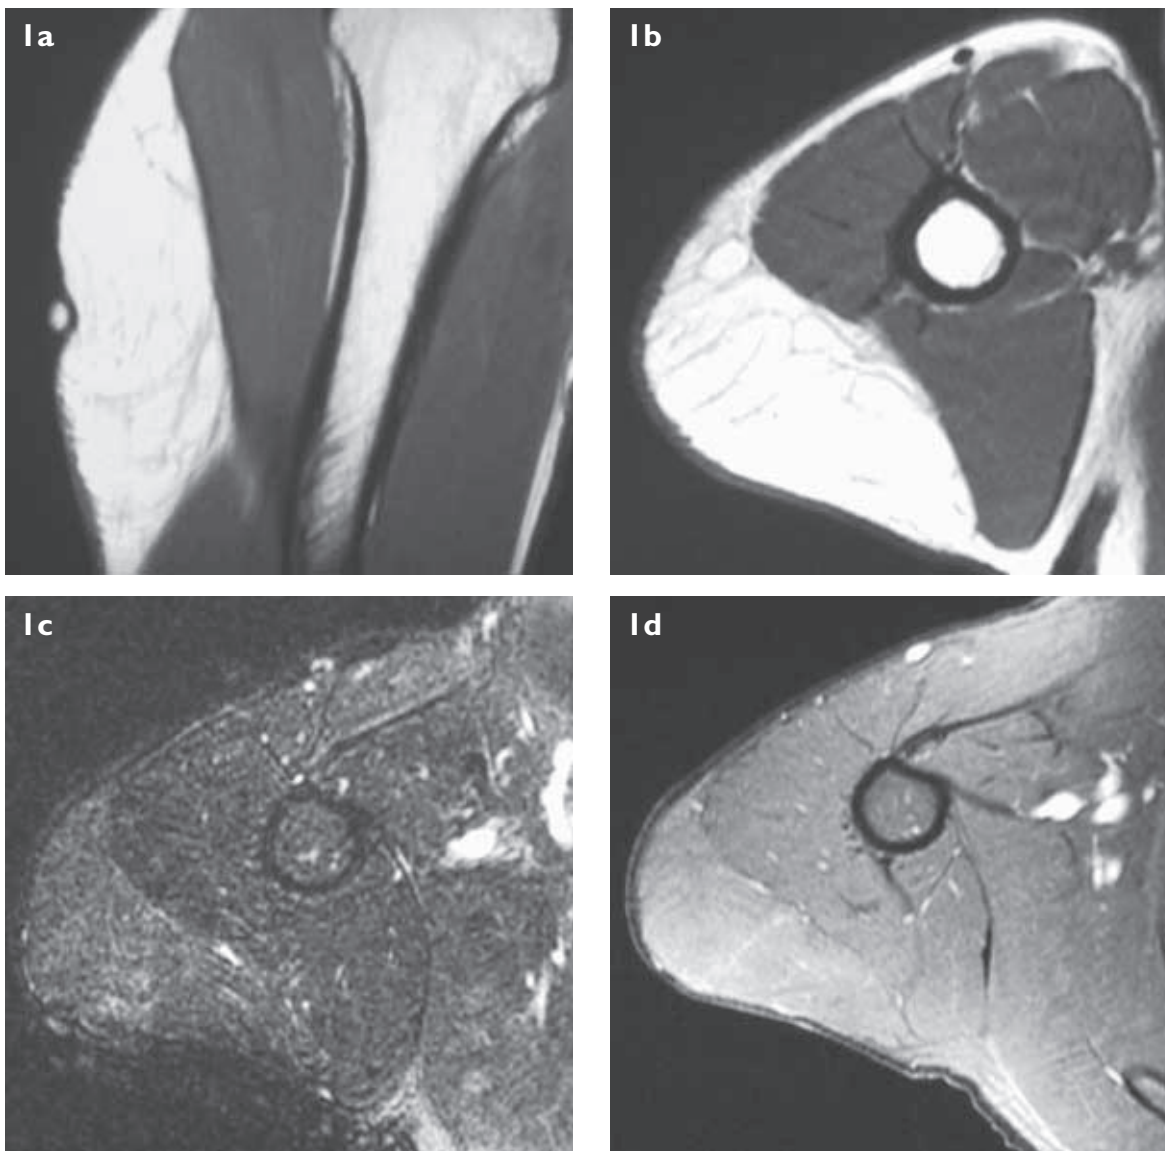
d (a) Coronal SE T1-W MR image of the right shoulder. Axial (b) SE T1-W, (c) fat-suppressed fast SE T2-W and (d) enhanced fat-suppressed SE T1-W MR images of the right shoulder. A surface marker is present.
